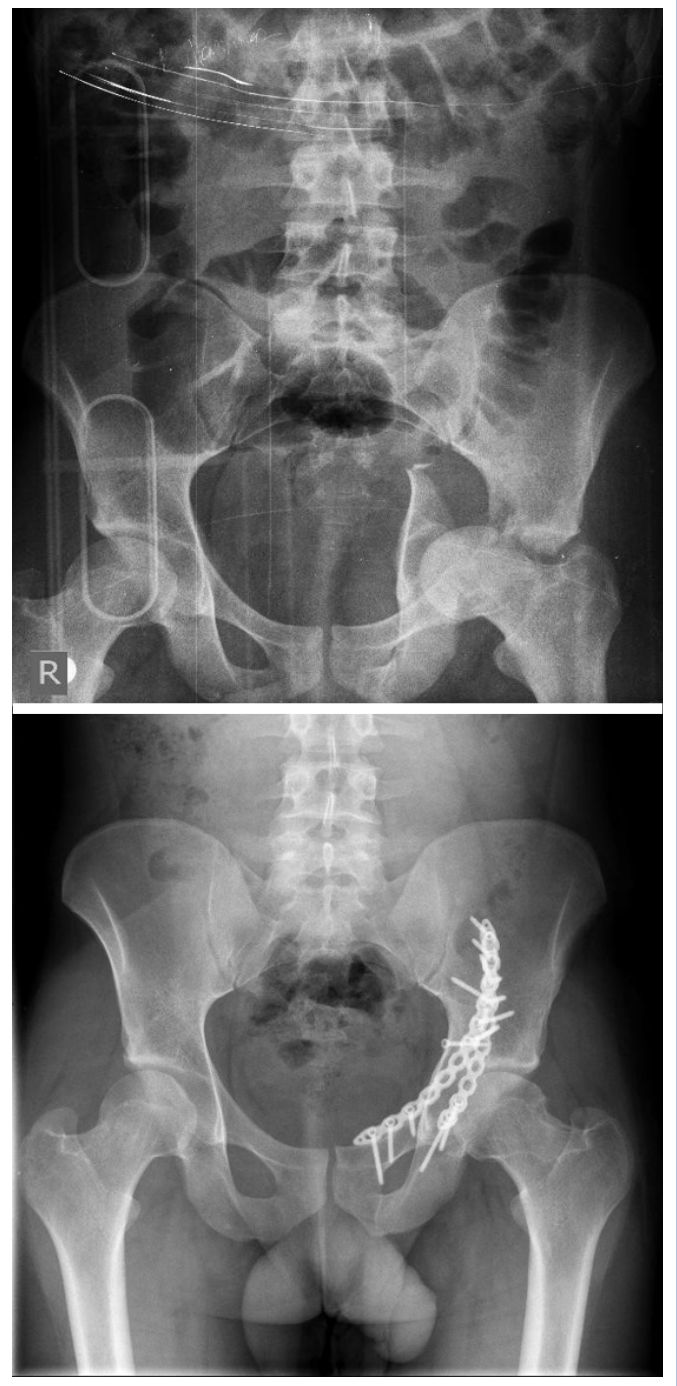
Preoperative and postoperative radiographs of a 22-year-old male patient who underwent an operation with the modified Stoppa approach.
